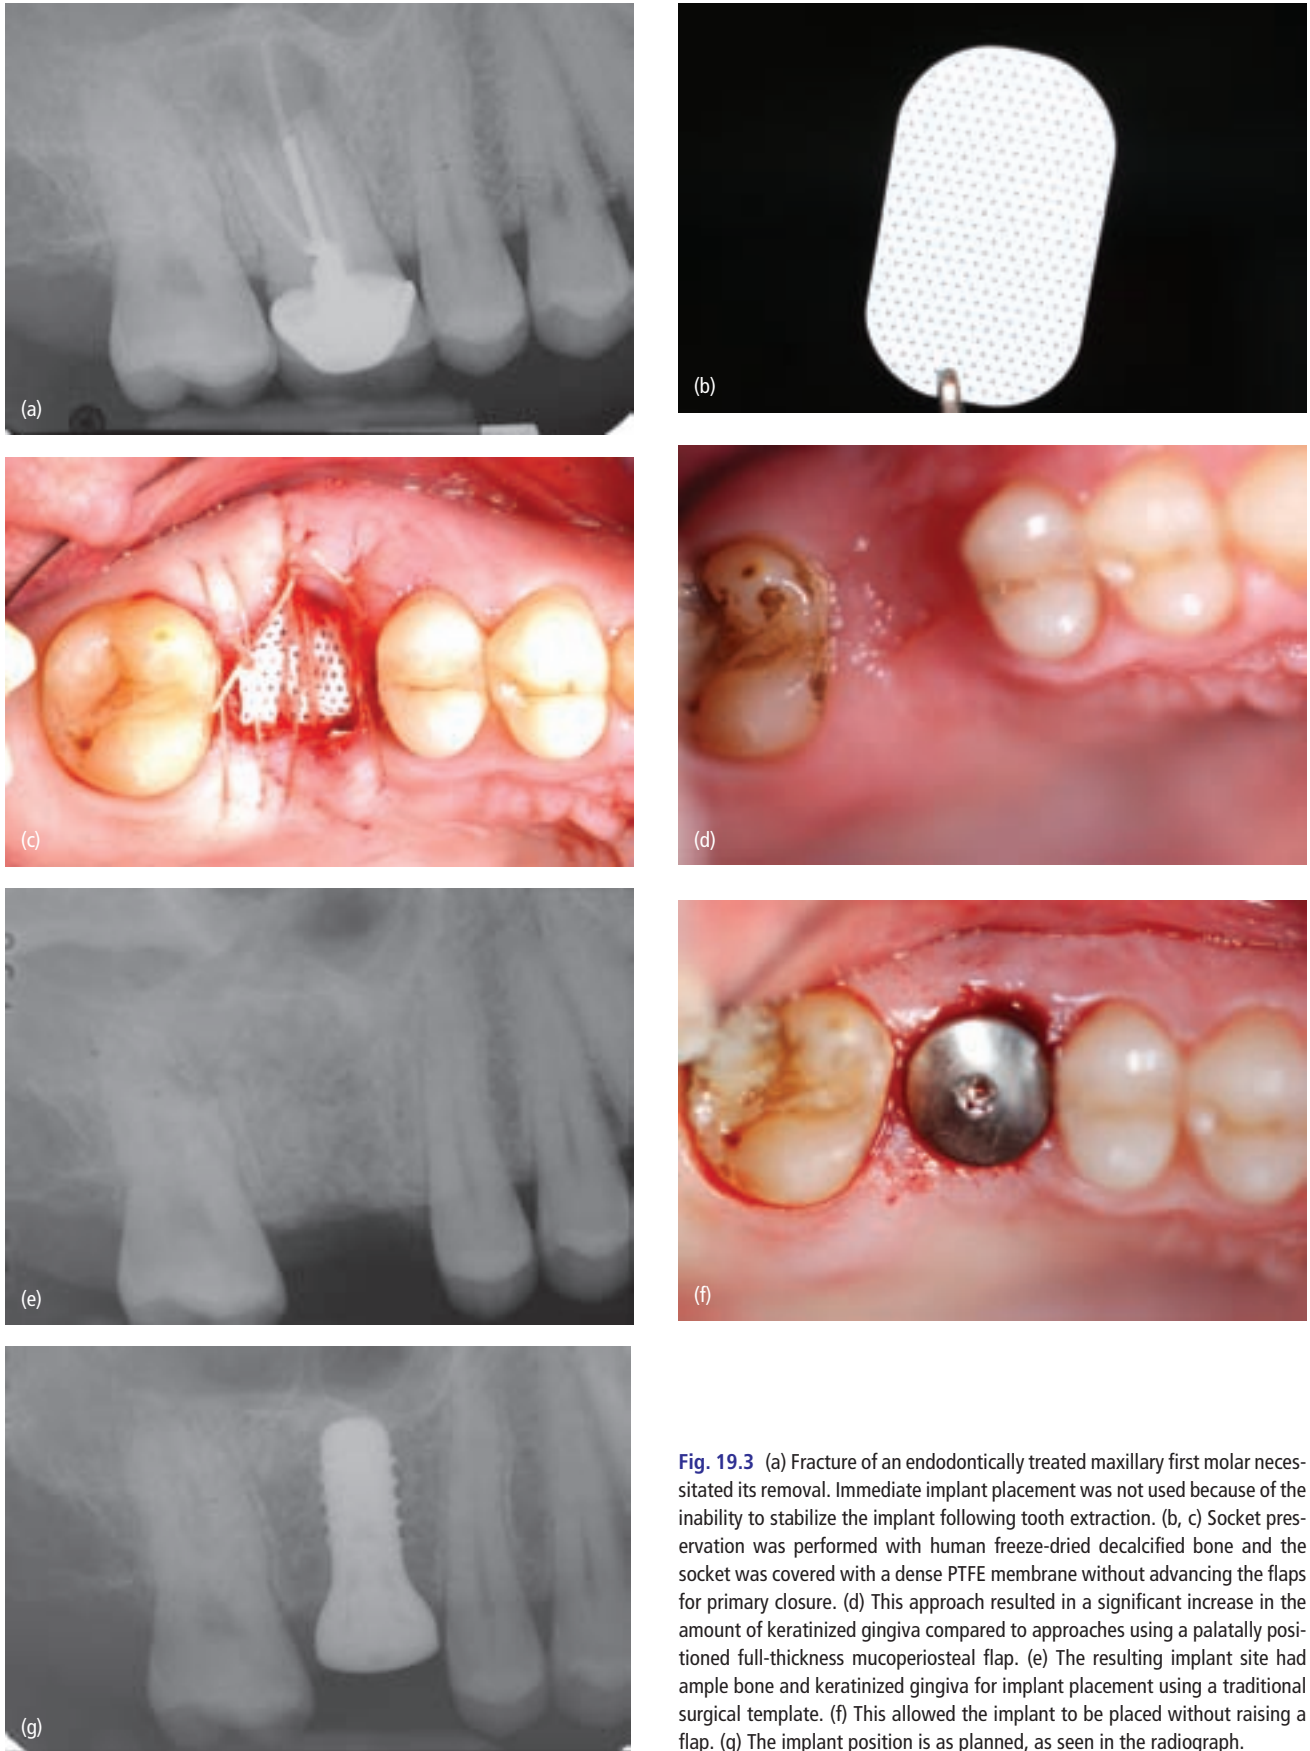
(a) Fracture of an endodontically treated maxillary first molar necessitated its removal. Immediate implant placement was not used because of the inability to stabilize the implant following tooth extraction. (b, c) Socket preservation was performed with human freeze-dried decalcified bone and the socket was covered with a dense PTFE membrane without advancing the flaps for primary closure. (d) This approach resulted in a significant increase in the amount of keratinized gingiva compared to approaches using a palatally positioned full-thickness mucoperiosteal flap. (e) The resulting implant site had ample bone and keratinized gingiva for implant placement using a traditional surgical template. (f) This allowed the implant to be placed without raising a flap. (g) The implant position is as planned, as seen in the radiograph.
